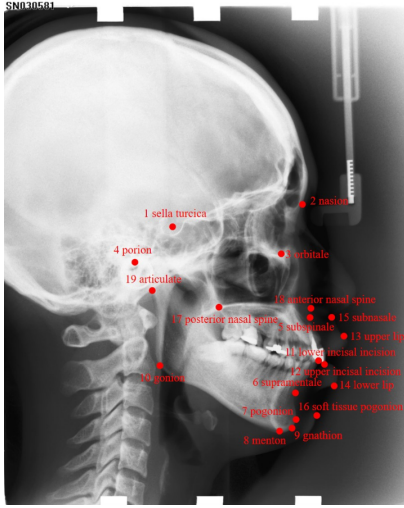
Overview of a Cephalometric X-Rays labelled. Image from 'Automatic Cephalometric Landmark Detection on X-Ray Images Using a Deep-Learning Method' [18] to show the different kind of landmarks.
